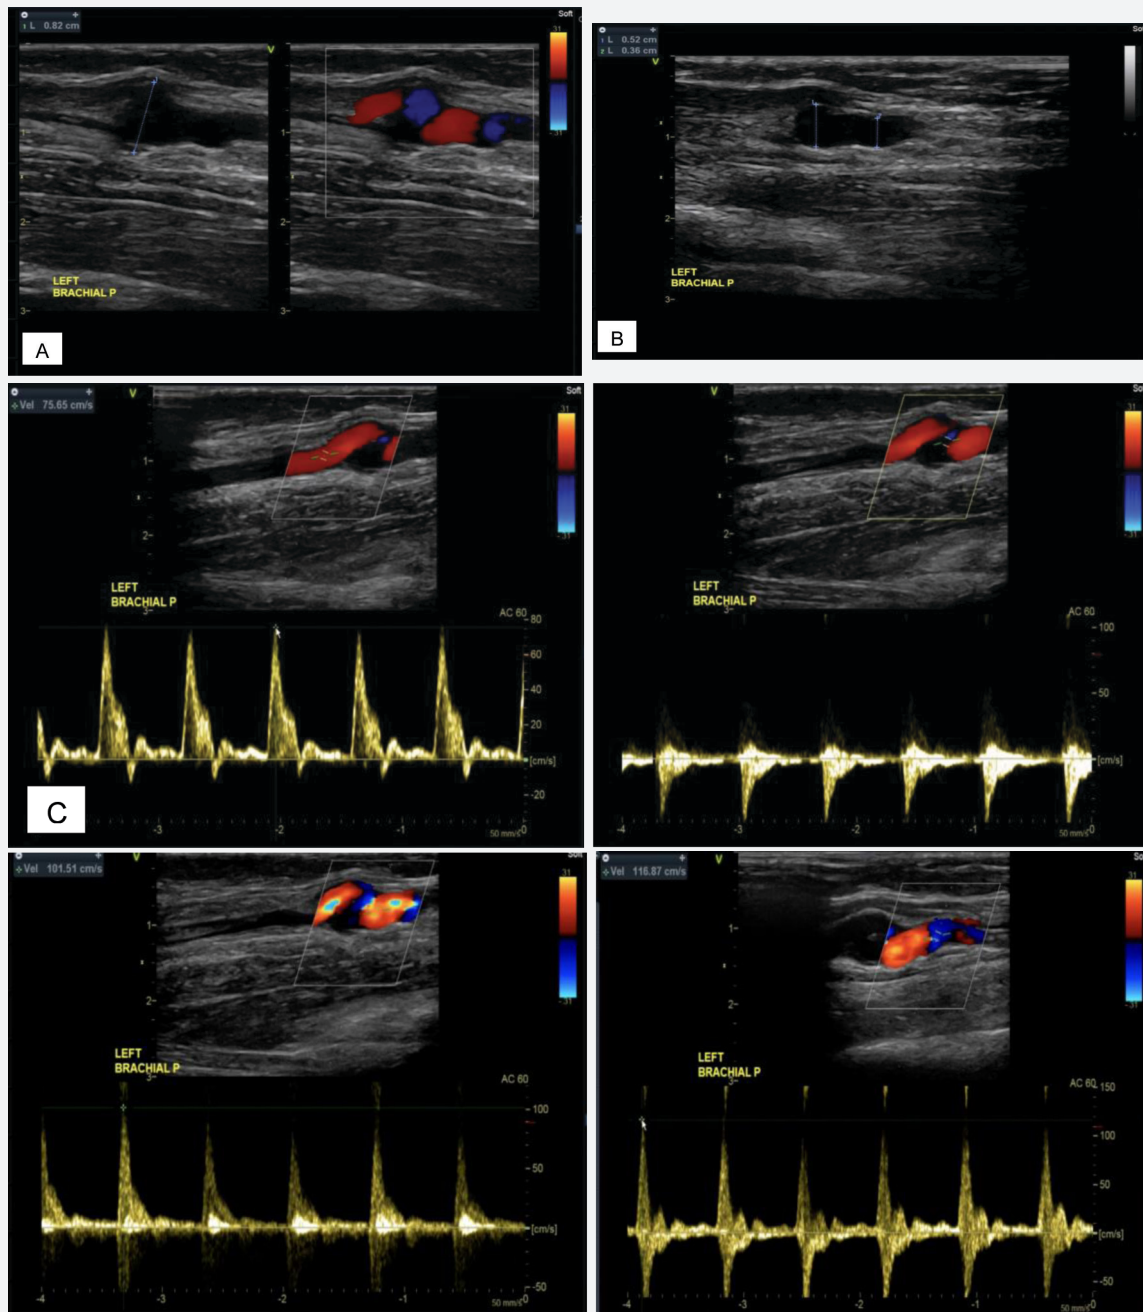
Arterial duplex scan of the left upper extremity. A. Long axis view at the level of the proximal brachial artery, there is note of focal dilation but no areas of stenosis, plaque or intimal thickening. B. The dilated segment is followed by some widening and narrowing of the arterial segments. C. The color flow study of the left brachial artery in the dilated segment showed a delineation between the red and blue color. The blue color indicates a retrograde flow of blood while the red color indicates a forward flow of blood. As the blood flows forward, notice that the color flow is disturbed and becomes turbulent as it passes to the alternating narrowed and dilated segments. The Doppler study showed a forward and reversal waveform pattern.
